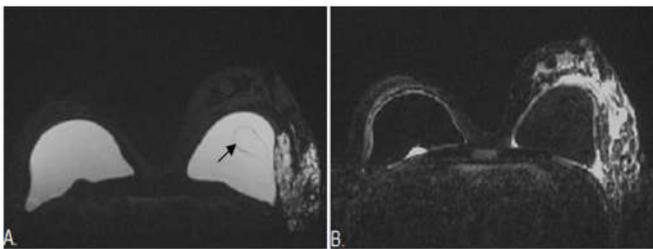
Bilateral single lumen silicone implants. On the patient's left there is intracapsular and extracapsular rupture. (A) Axial water-suppressed fast spin echo T2-weighted MRI (TR 5200, TE 304, 4mm slice thickness, FOV 20cm) silicone only image demonstrates a linguine sign (arrow) also there are droplets of silicone signal within the breast tissue lateral to the implant. (B) Axial, silicone suppressed T1-weighted MRI (TR 950, TE 11, 4mm slice thickness, FOV 20cm) fluid only image confirms the presence of extra capsular silicone, which now returns low signal. There is also considerable oedema of the breast tissue (Potterton, 2002).
